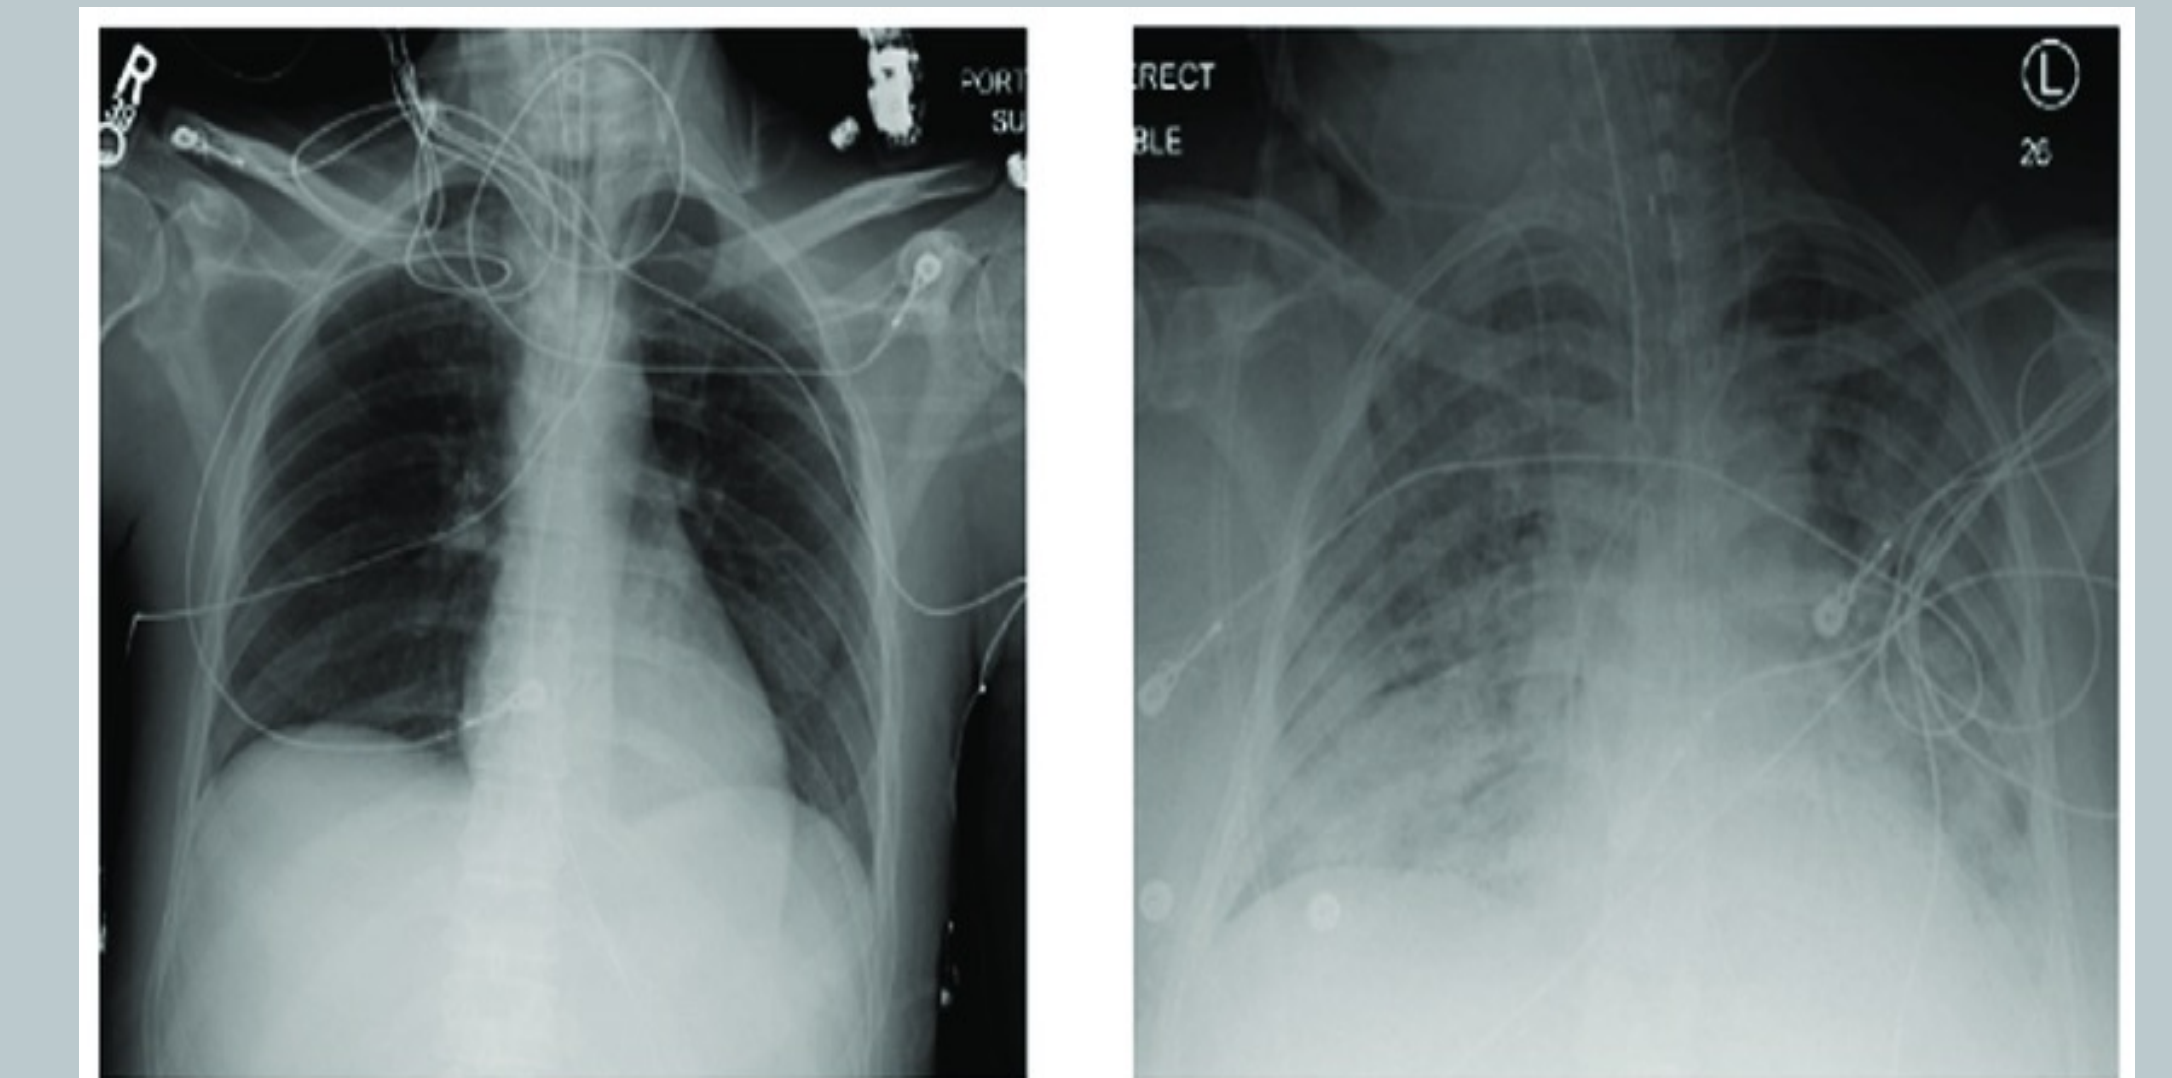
Chest x-ray of healthy lungs (left). Chest x-ray of acute chest syndrome (right).
